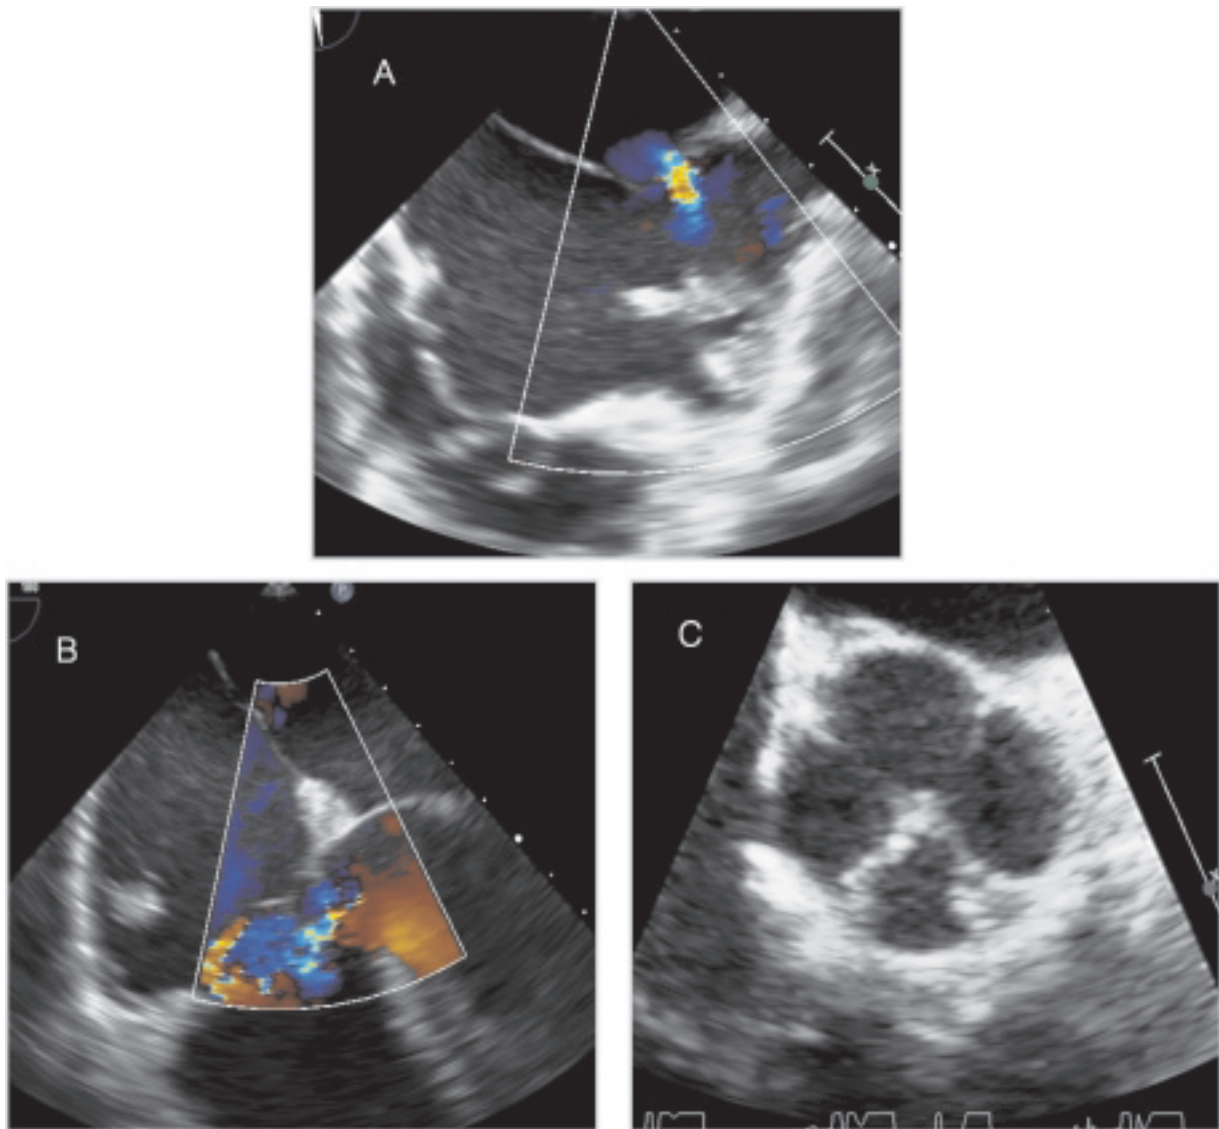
Multiple congenital abnormalities. Panel A, Midesophageal bi-caval view with color-flow Doppler demonstrating the secundum-type atrial septal defect with a left-to-right shunt. Panel B, Midesophageal 4-chamber view with color-flow Doppler showing a perimembranous ventricular septal defect with a left-to-right shunt. Panel C, Quadricuspid aortic valve.
